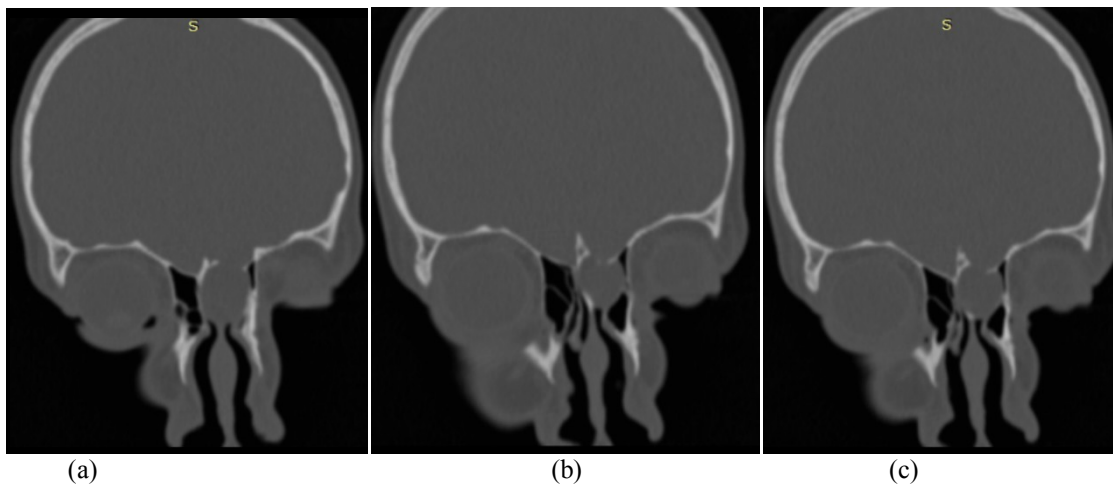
Coronal CT bone window images (a,b,c) showing defect in the cribriform plate on left side.
